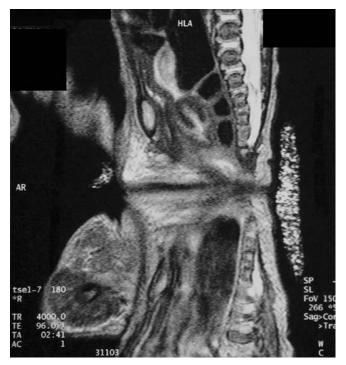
Sagittal T2-W MRI showing ischiopagus twins with fusion of the perineum, but their sacra and spinal canals are separate
